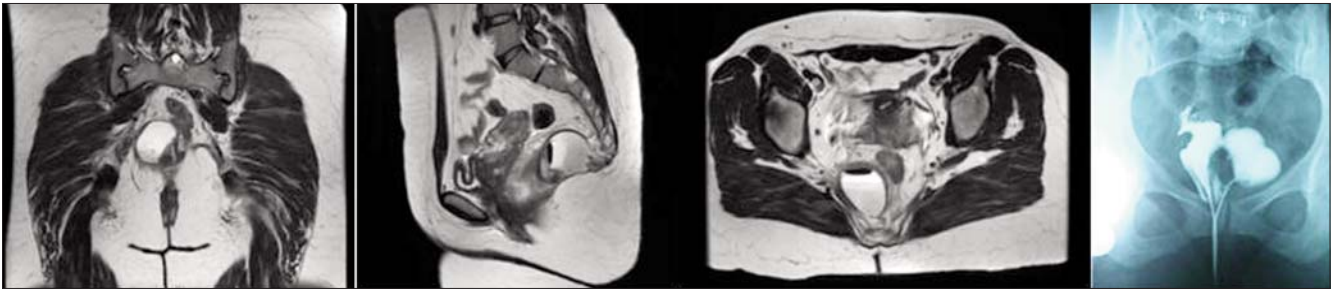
MRI and fistulography
